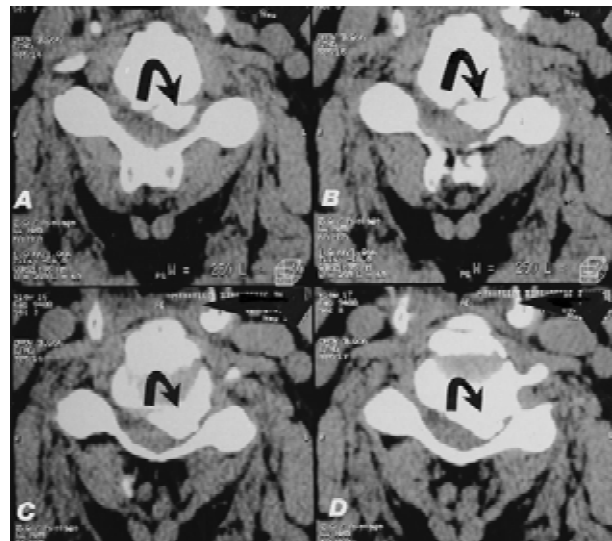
A preoperative transaxial noncontrast CT study shows massive continuous OPLL at the C4–C5 level in a patient with C3–C7 disease (case 2). A: At the C4–C5 disk space, a solid mass of OPLL (arrow) fills the ventral and left side of the spinal canal, causing marked cord and C5 root compression. B: The mass of OPLL (arrow) nearly touches the lamina at the C4–C5 disk space. C: In the C4–C5 inferior disk space, the OPLL mass (arrow) more clearly extends across the midline. D: In the C4–C5 inferior disk space, the OPLL mass (arrow) nearly obliterates the left side of the spinal canal and foramen, resulting in significant right-sided cord and nerve root compression.
